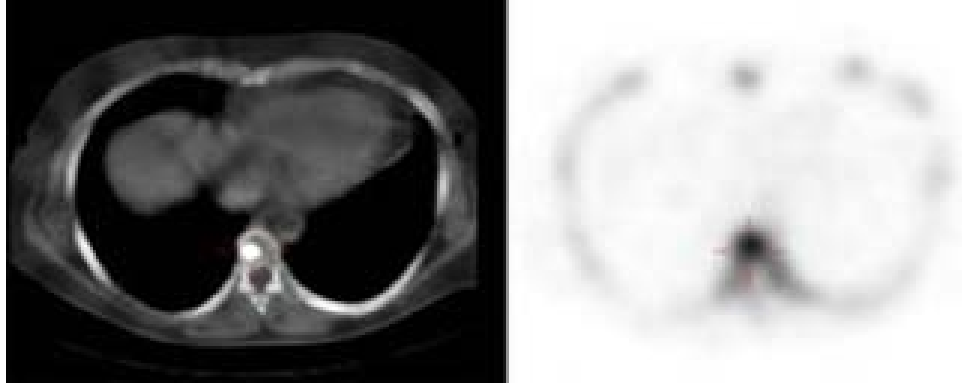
Traverse Thoracic image from CT and corresponding ^{99m}Tc -FDP SPECT image showing increased Focal uptake in thoracic spine.
